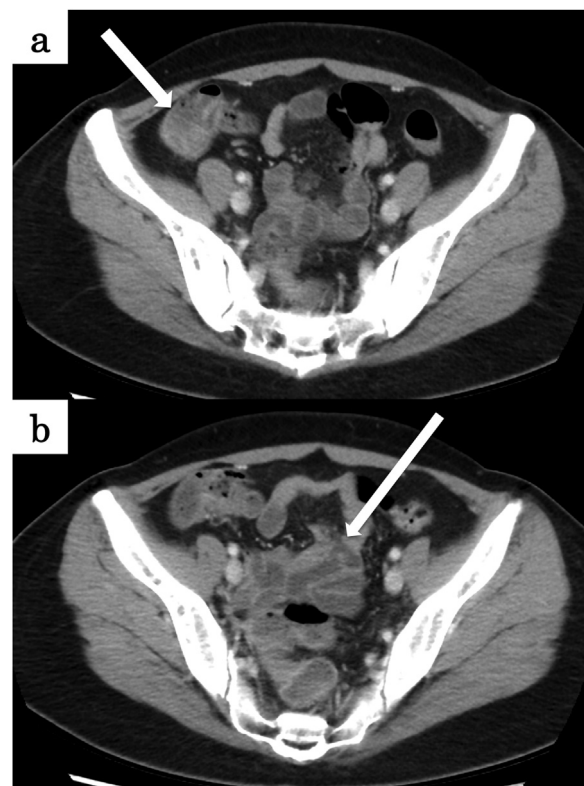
Contrast-enhanced computed tomography of the abdomen revealed non-specific inflammation of the large intestine (a) and small intestine (b) (white arrow).
